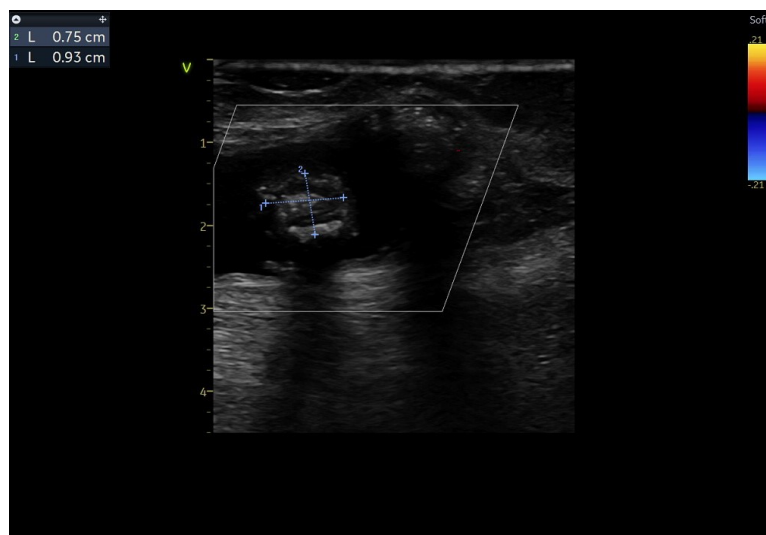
Doppler of Left popliteal artery
